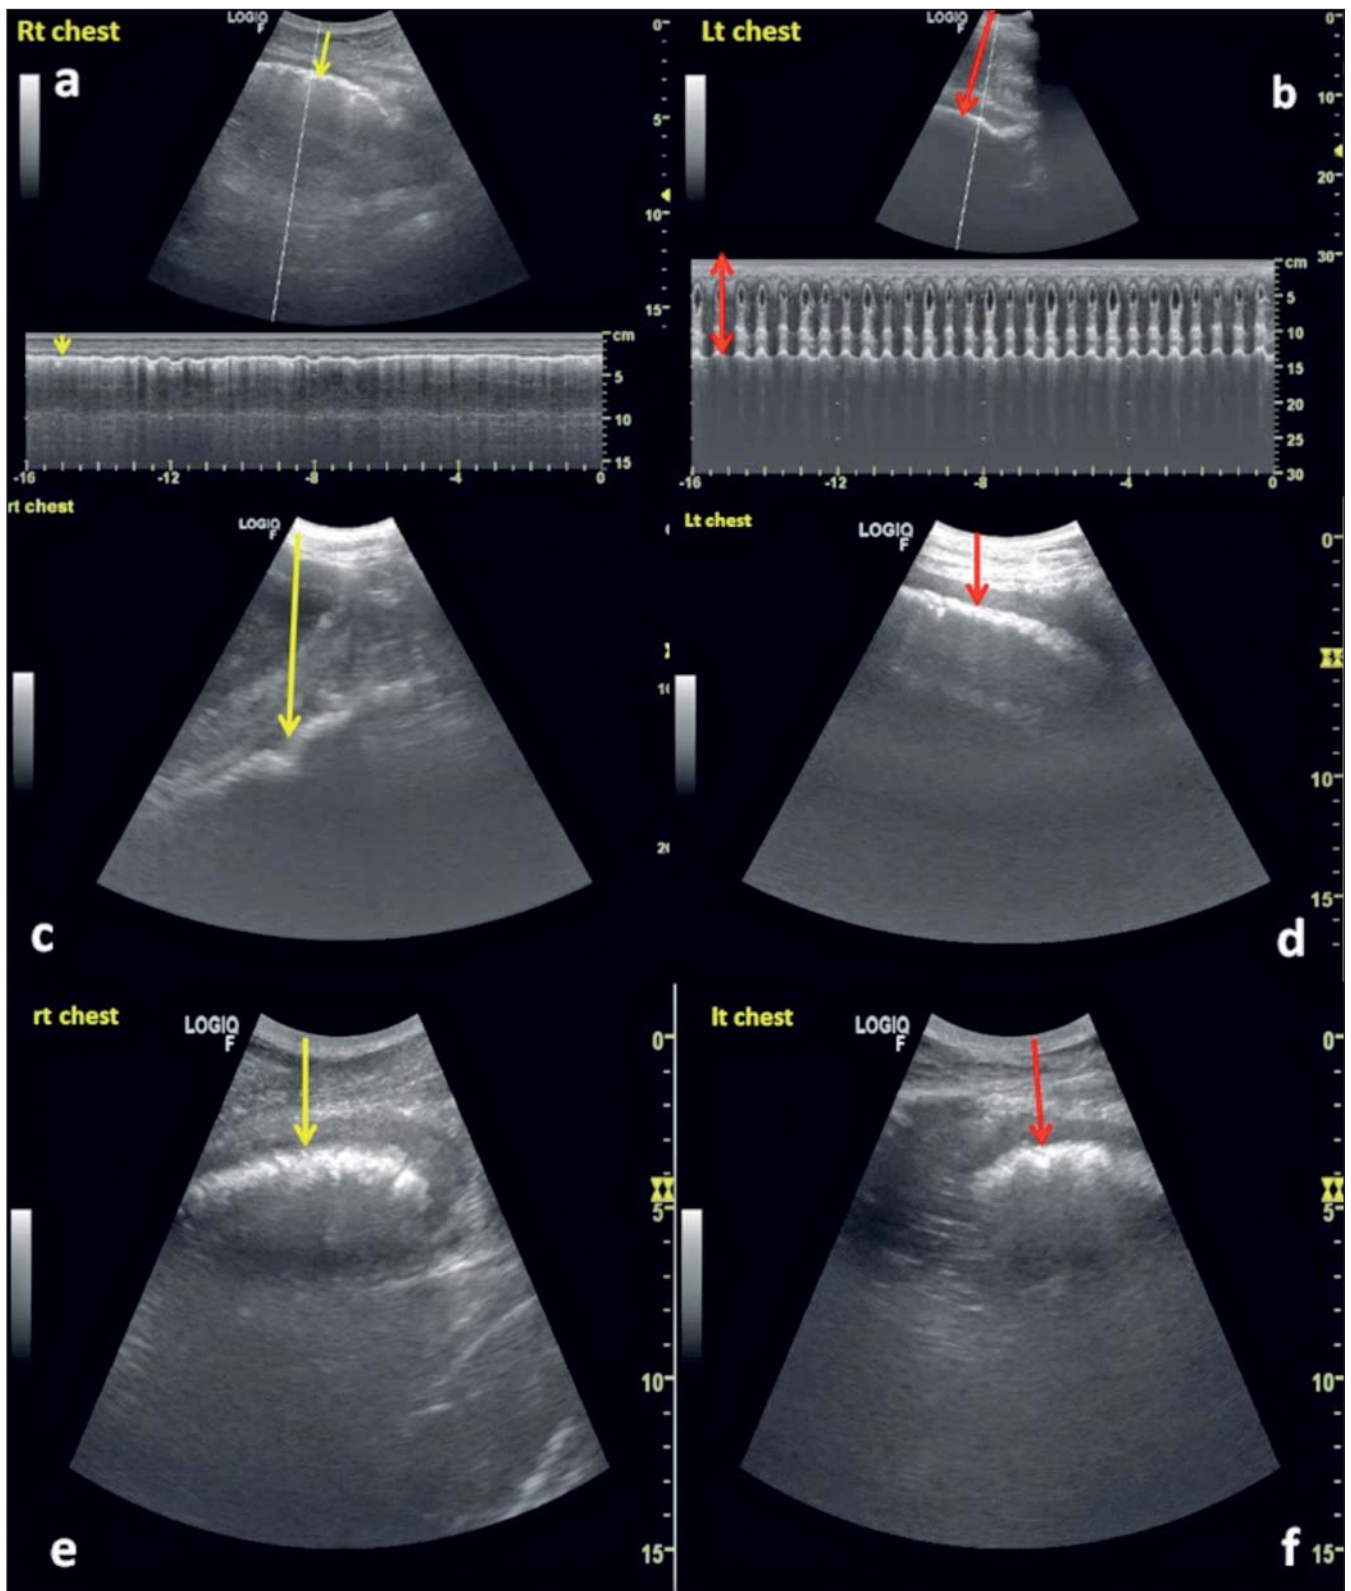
Ultrasonogram showing the reticular wall close to the thoracic wall from the right chest window (a) and away from the left chest (b) in Group 1 buffalo. The reticular wall is seen away from the thoracic wall from the right chest window (c) and close from the left chest (d) in Group 2 buffalo. The reticular wall is seen close to the thoracic wall from both the right (e) and the left (f) chest windows in Group 3 buffalo.
